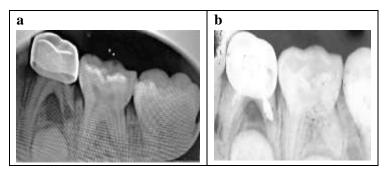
a: post-operative radiograph of primary first molar with partial pulpotomy after 6 months showing bone and root resorption, b: re-treatment for the tooth using pulpectomy technique.
